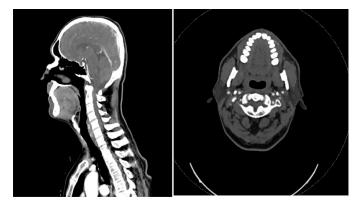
1st patient pre-operative CT CT: Computed tomography
